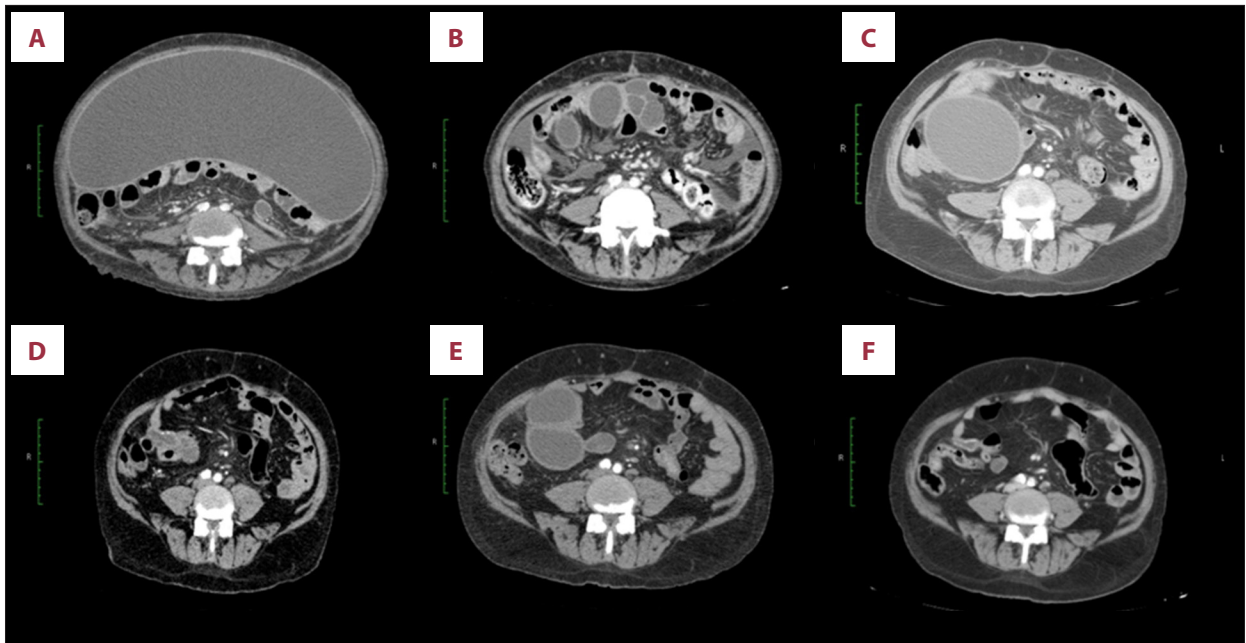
(A, B) CT scan image of the voluminous peritoneal cyst at the arrival in our Division. (C) CT scan image after four months laparotomy to remove the multiple cystic peritoneal formations performed. (D) CT image six months after rapamycin therapy. (E, F) The last CT image 24 months after rapamycin therapy.
